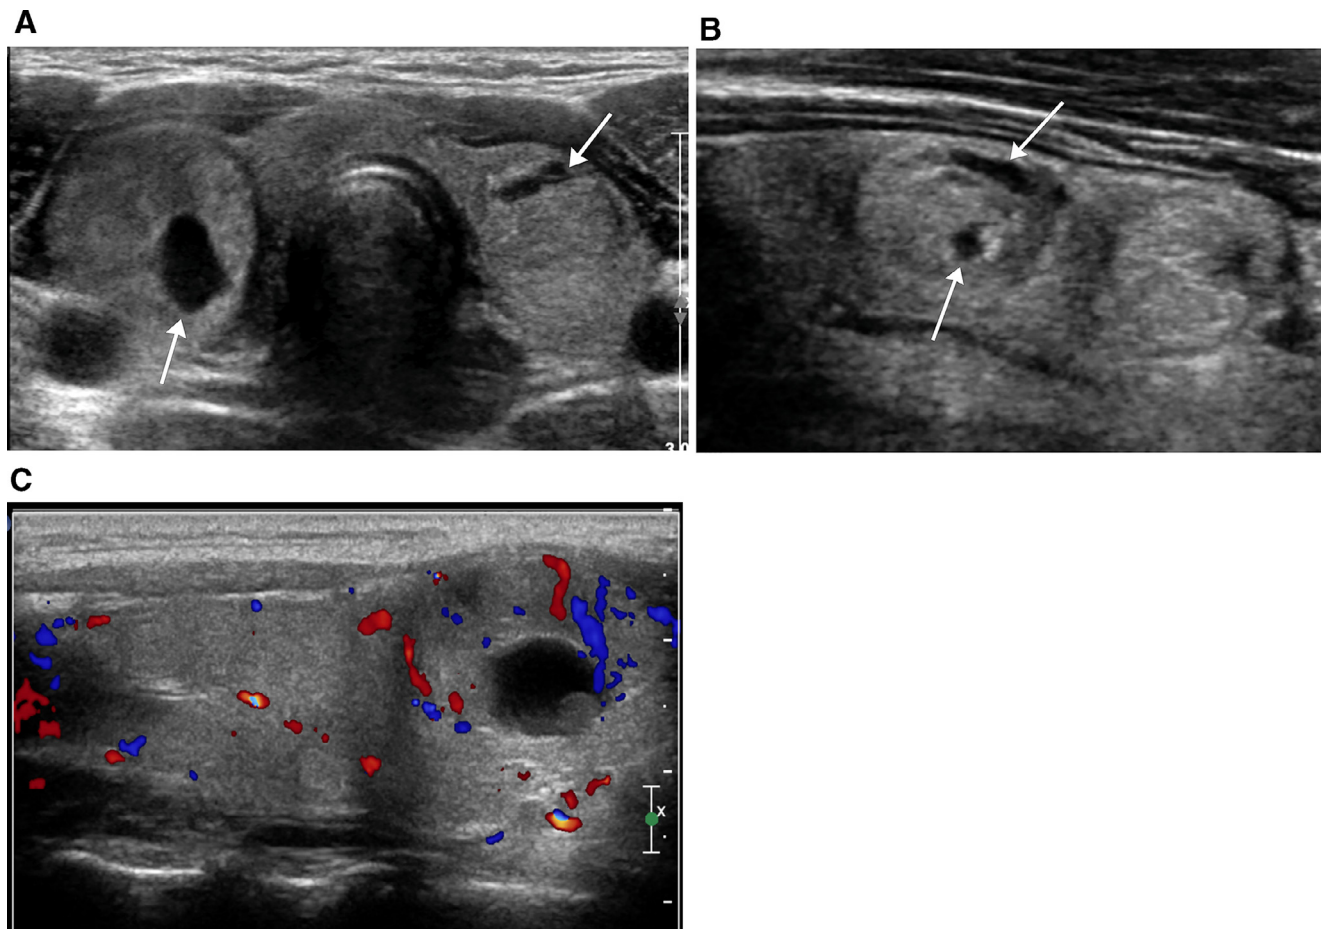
Nodular hyperplasia. Eleven-year-old girl with thyroid enlargement on physical examination. Transverse (A) and sagittal (B, C) gray scale ultrasound images show an enlarged gland with numerous slightly echogenic nodules that contain areas of presumed liquefaction (arrows). The nodules have increased flow on color Doppler, but overall parenchymal vascularity is normal (C). Fine-needle aspiration of the largest lesions in each thyroid lobe revealed hyperplastic nodules.
